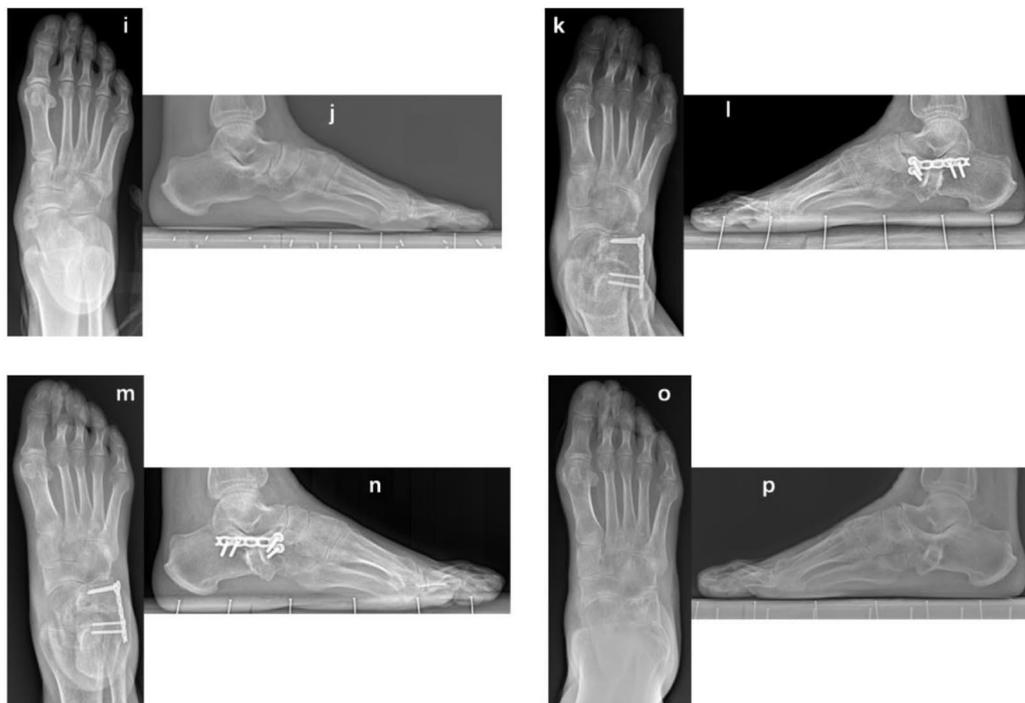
Radiographic comparison between H-LCL (A) and E-LCL (B) osteotomies. Both a 36-year-old male patient who received H-LCL osteotomy and a 41-year-old male patient who received E-LCL osteotomy decided to remove the internal fixation one year later. (a) and (b), (c) and (d), (e) and (f), (g) and (h) represent pre-surgery, post-surgery, 6 months post-surgery, 1 year post-surgery, respectively. (i) and (j), (k) and (l), (m) and (n), (o) and (p) represent pre-surgery, post-surgery, 6 months post-surgery, 1 year post-surgery, respectively
